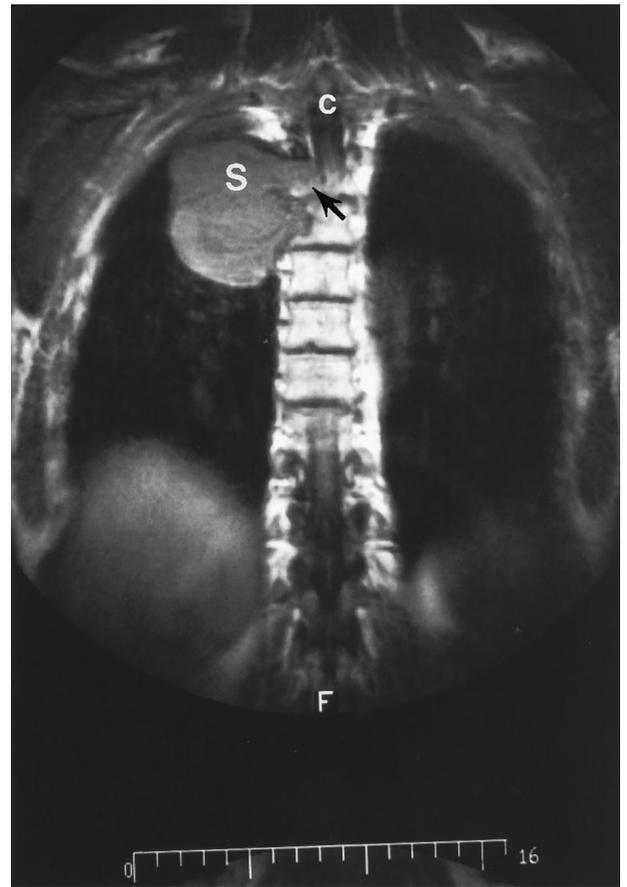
T<sub>1</sub>-weighted unenhanced coronal MRI in a 35-year-old man with chest pain. A well-circumscribed rounded schwannoma (S) has slightly heterogeneous signal intensity and intraspinal extension (arrow) with mass effect on the spinal cord (c).
